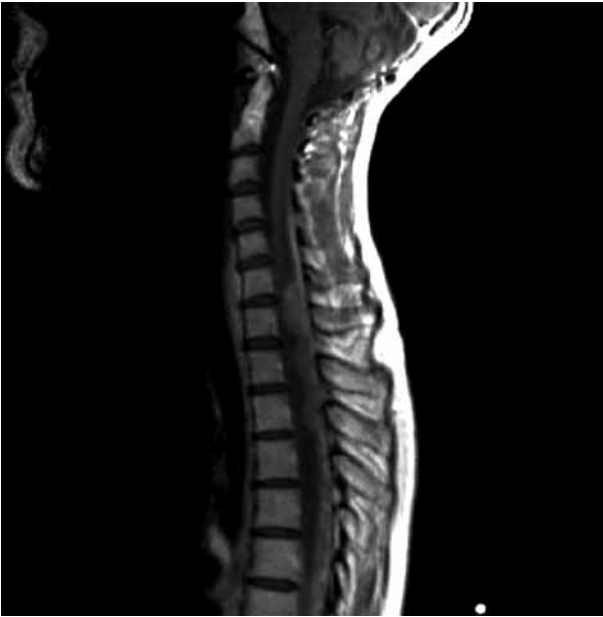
T1 weighted sagittal MRI before treatment, showing thoracic and cervical spread of the disease with tumour enhancement.
